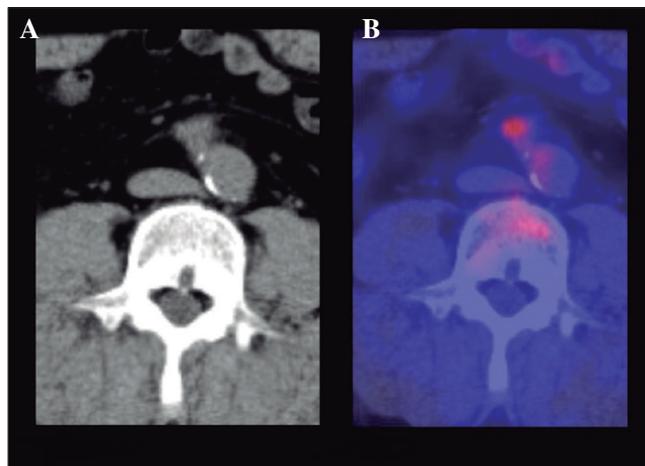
18-FDG PET-CT scan with a CT image (A) and a fusion image (B) focused on the lesion described in figure 1. A hypermetabolic "hot spot" with a high Standard Uptake Value (SUV) of 5.04 may be seen, which suggested retroperitoneal neoplastic involvement.
